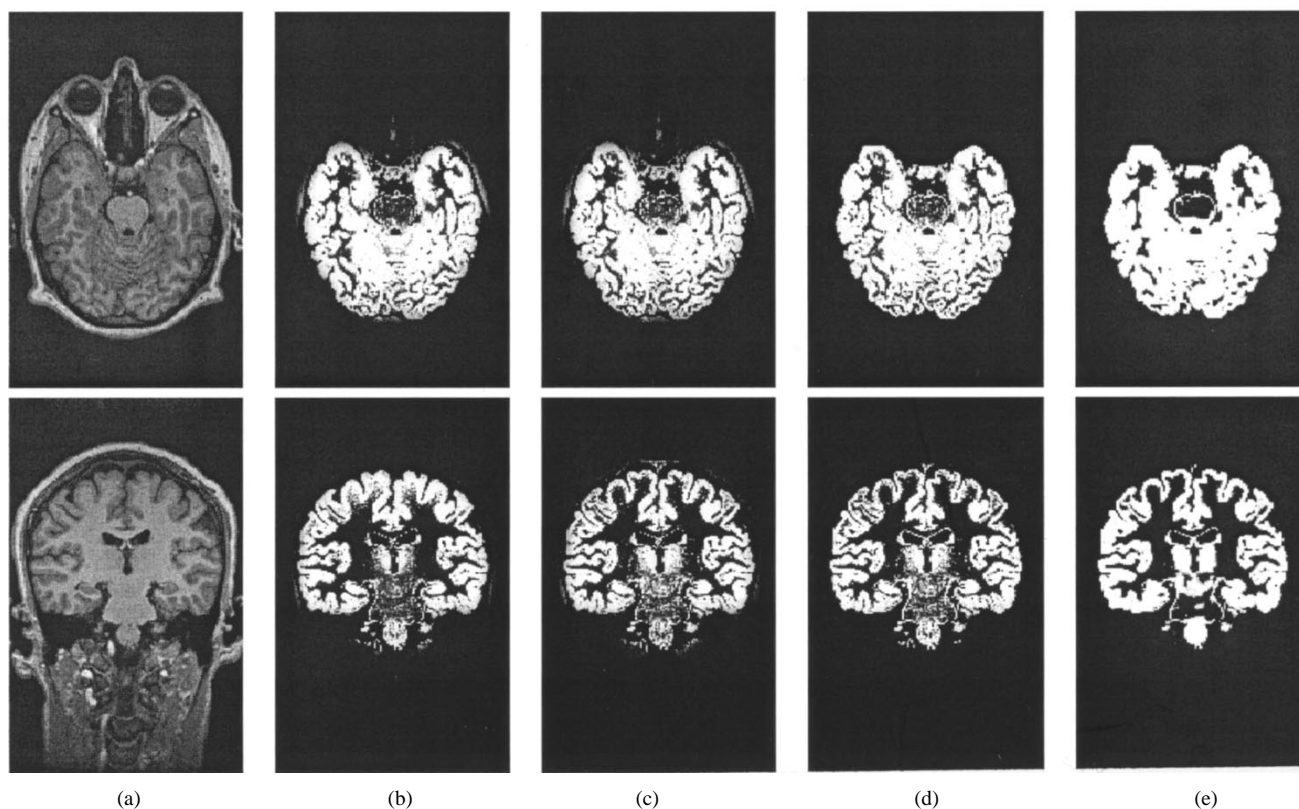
Example of how the different components of the algorithm work. (a) T1-weighted image. (b) Gray-matter segmentation without bias field correction and MRF. (c) Gray-matter segmentation with bias field correction but without MRF. (d) Gray-matter segmentation with bias field correction and MRF. (e) Gray-matter segmentation with bias field correction and MRF without constraints.
